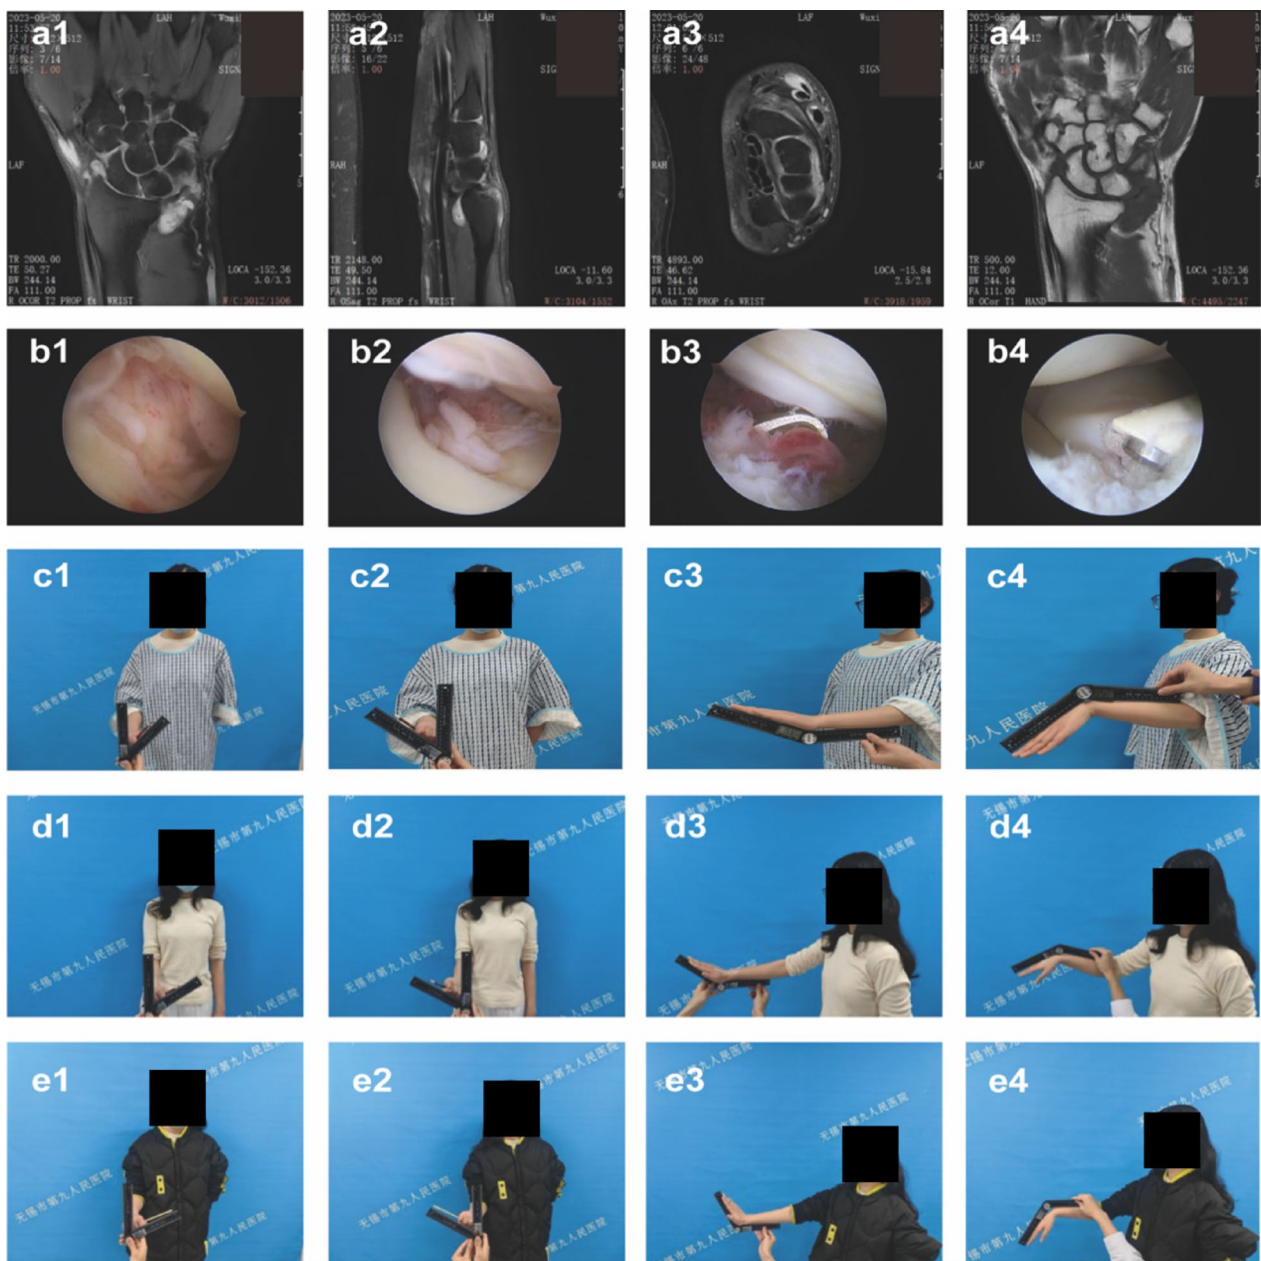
Preoperative MRI, arthroscopic findings, and follow-up assessments of wrist range of motion in a representative case of wrist synovitis. a1–4, Preoperative MRI images of the affected wrist, demonstrating abnormal masses near the distal radioulnar and radiolunate joints. b1–4, Arthroscopic images showing inflammatory synovial proliferation and the debridement procedure. c1–4, Preoperative range of motion measurements of the affected wrist. d1–4, Range of motion measurements at two weeks postoperatively. e1–4, Range of motion measurements at four weeks postoperatively
